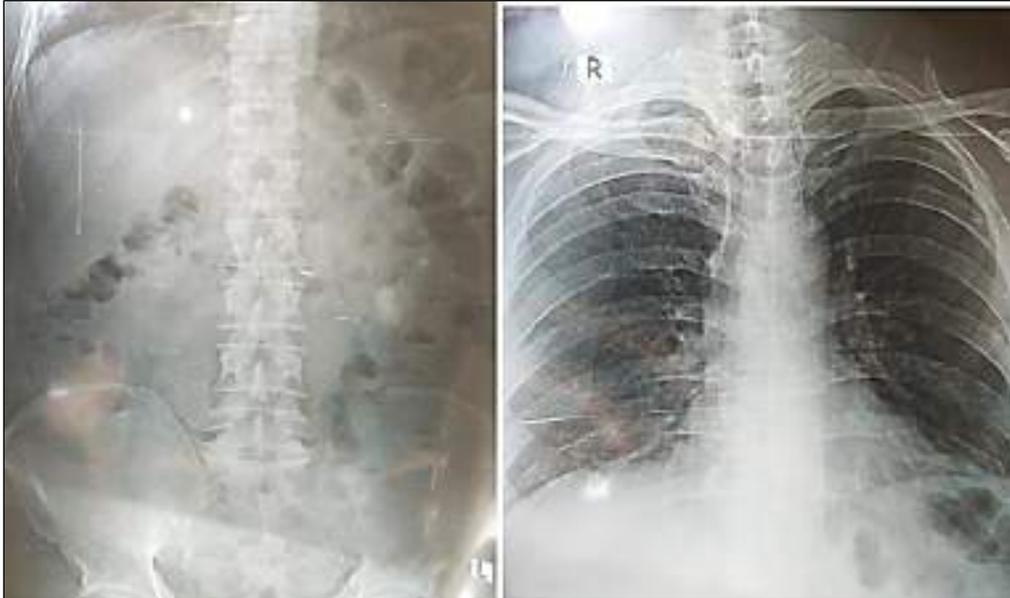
Supine abdominal X-ray showing air in gut loops. An erect chest X-ray shows no air under the diaphragm
